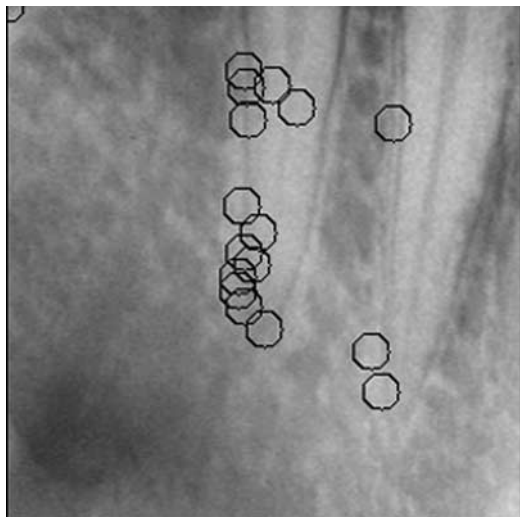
Example of fixation locations on a radiograph that shows widened ligament space. A circle with a diameter of 0.75 visual degrees represents each fixation. (Reprinted, with permission, from reference 35.)
